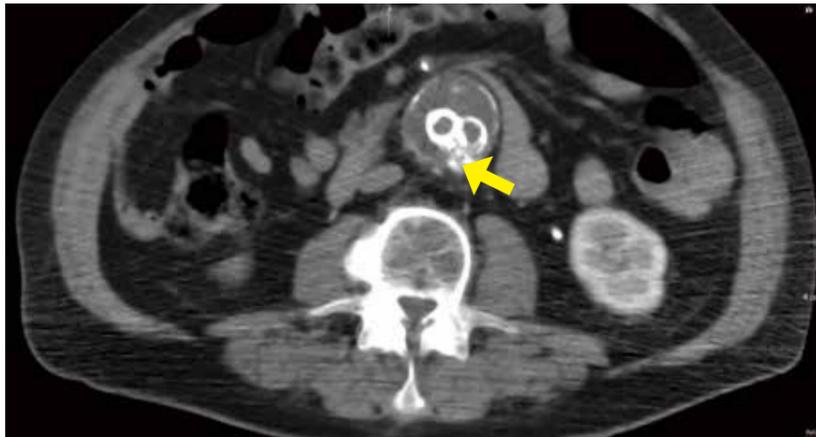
CT scan helped to confirm area of endoleak.
